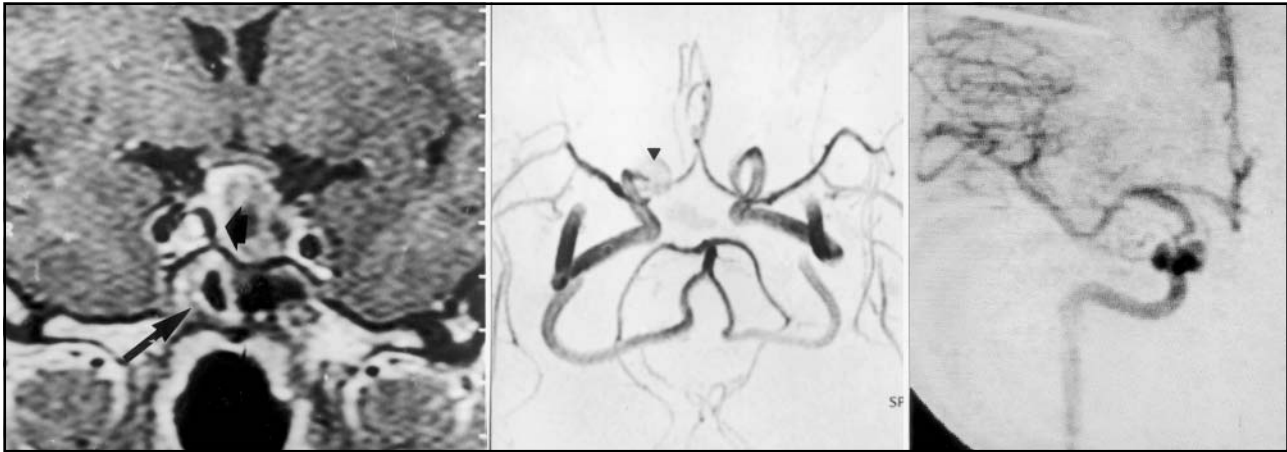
A. MRI T1 coronal showing a parasellar mass next to the right cavernous ICA, invading the sellar compartment and with a flow void rim (arrowhead). A macroadenoma with supra-sellar extension and optic chiasm distortion surrounded by a layer of hyperintense signal. There was also enhancement of the adjacent right chamber of the sphenoid sinus wall (arrow). B. MRA depicting vascular lesion at the cavernous segment of the ICA. C. Digital Angiography with the false aneurysm.
